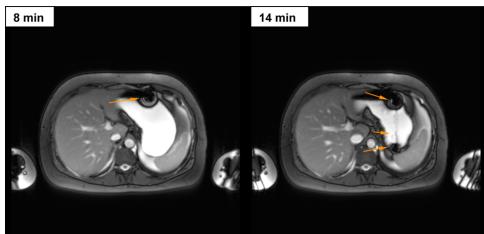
Transversal MR image of the abdomen taken 8 min (left) and 14 min (right) after the oral administration of a hard gelatin capsule marked with 5 mg iron oxide together with 240 mL of water. In the left image, the capsule position inside the stomach can be identified by the black artifact (orange arrow), which gives a sharp contrast against the bright gastric content. It can be seen that the capsule is floating on the top of the gastric content. In the right image, additional artifacts occurred as indicated by the orange arrows. A smaller second artifact was located at the bottom part of the stomach, which indicated the disintegration of the capsule because some parts of the incorporated iron oxide could leave the capsule. These sedimented at the bottom part of the stomach and most probably caused the additional artifact.
